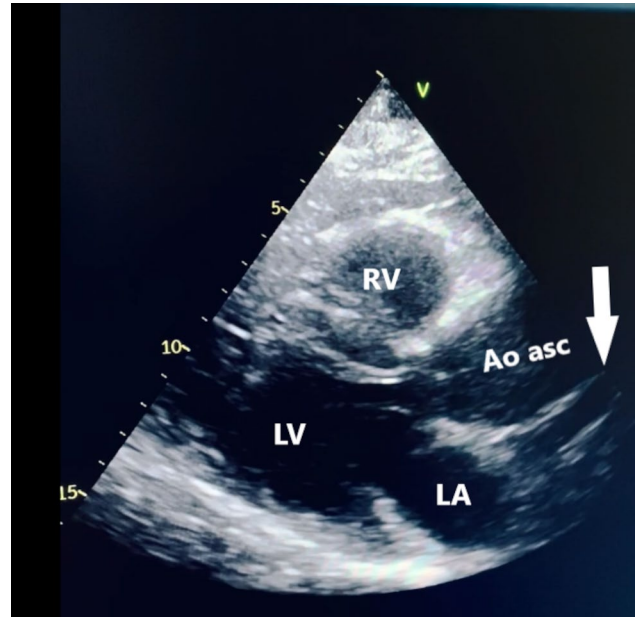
Point-of-care echocardiography of the parasternal long-axis projection: the ascending aorta is dilated at the dissection site, with intimal delamination (white arrow), leading to the formation of true and false vascular lumina
